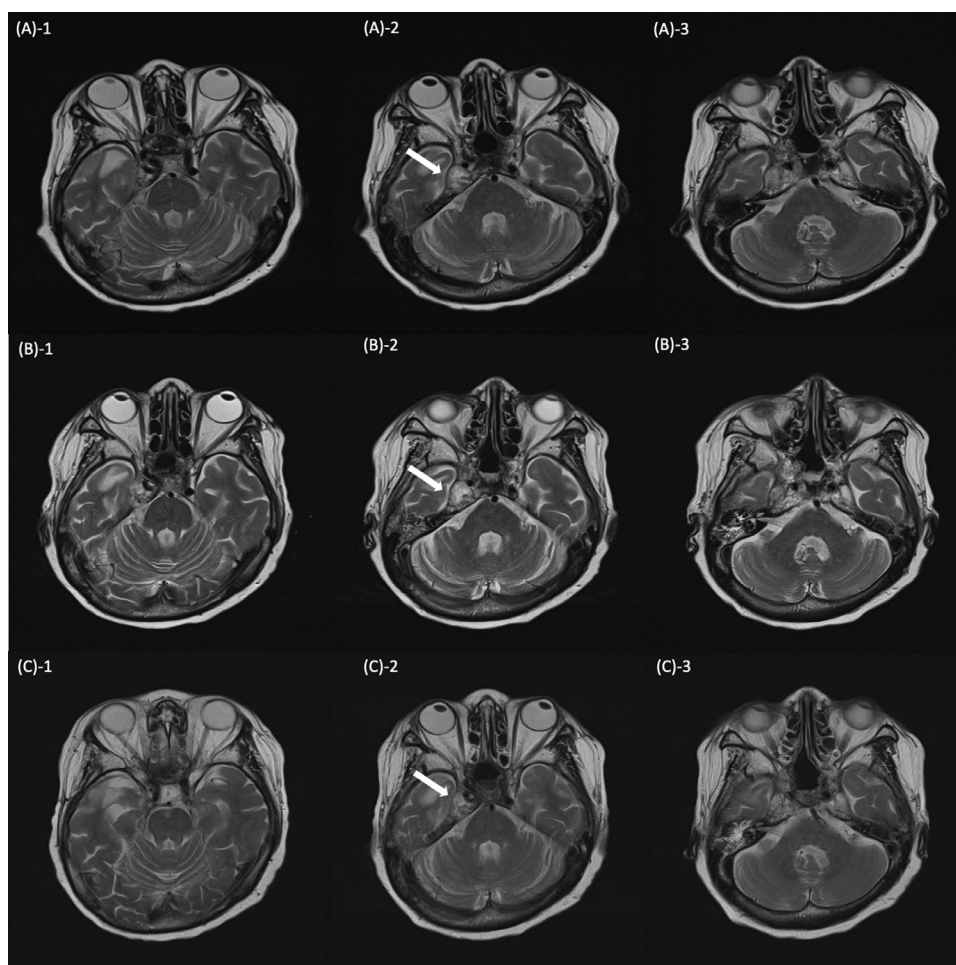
T2-weighted brain magnetic resonance imaging axial view with a 4 mm slice thickness for clival chordoma. (A) Imaging on June 24, 2023, before boron neutron capture therapy (BNCT), (B) on December 22, 2023, after the first BNCT, and (C) on May 13, 2024, after the second BNCT. In all 3 series (A-C), image 2 represents the slice showing the tumor at its largest dimension, while images 1 and 3 correspond to magnetic resonance imaging slices taken 4 mm above and below image 2, respectively.
